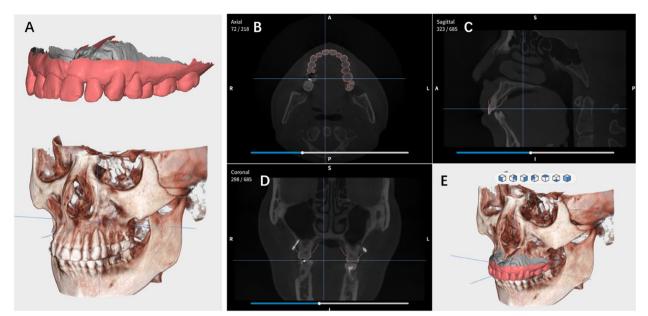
Alignment of the dental model based on CBCT. A Dental model and CBCT image at the same time; B axial view of alignment; C sagittal view; D coronal view; E 3D view of alignment
